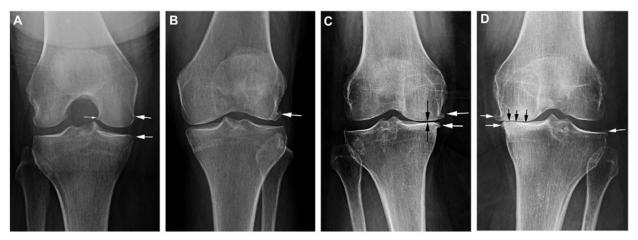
Radiographic Signs of Osteoarthritis. Hayashi 2016
